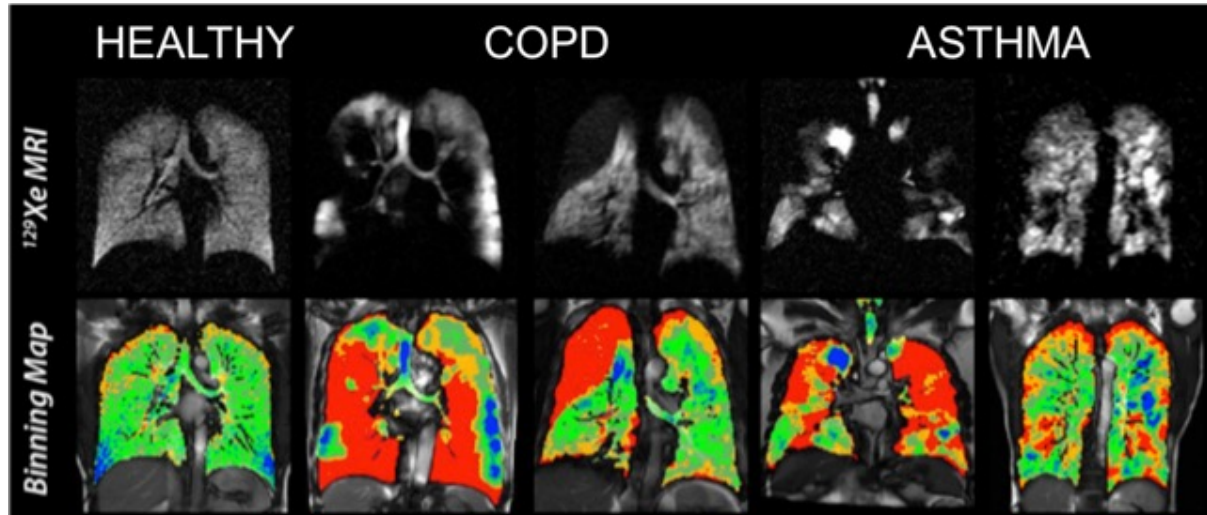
Hyperpolarized MRI scans (with Xe gas) of healthy and diseased lungs
